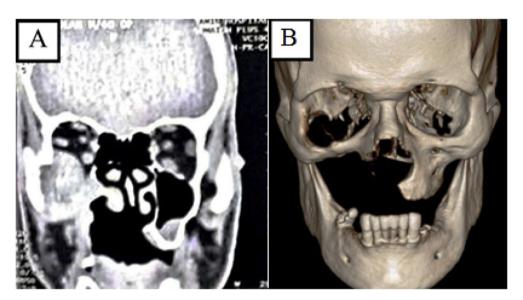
A: Computed tomography (CT) scan in January 2014; B: Three-dimensional reconstruction image.
